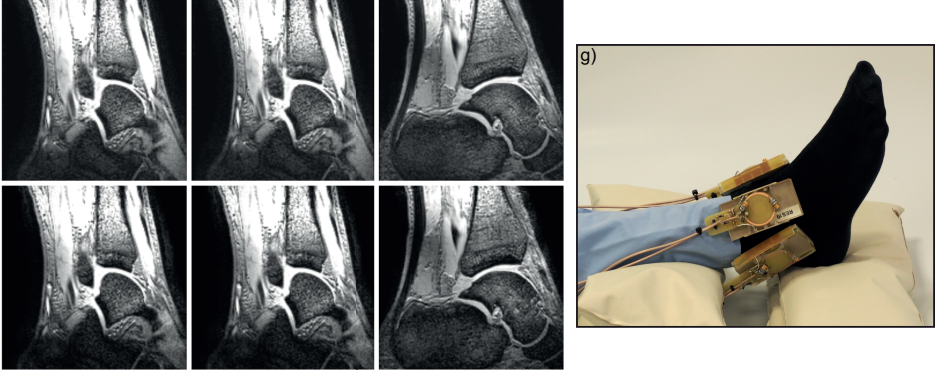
Three slices from a 3D T1-weighted gradient echo sequence of a human ankle, data matrix $160 \times 160 \times 80$, 0.75 mm isotropic spatial resolution, TE 2.8 ms, TR 10 ms, FA 10 degrees. (a)(c) without acceleration. (d)(f) a reduction factor of 1.5 in two directions. A four element detunable dielectric resonator array was used for signal reception as depicted in figure (g).
